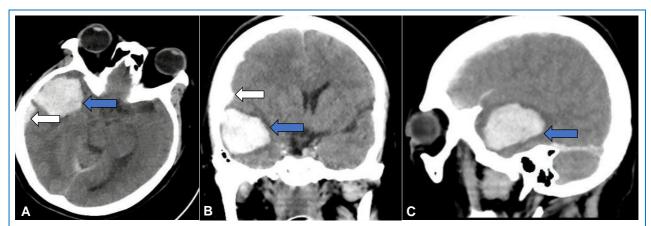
Brain tomography (CT) without contrast in (A) axial view, (B) coronal view and (C) sagittal view, where a right temporal hematoma (blue arrow) with perilesional edema, mass effect and midline deviation is showed; in addition to a laminar subdural hematoma (white arrow).
